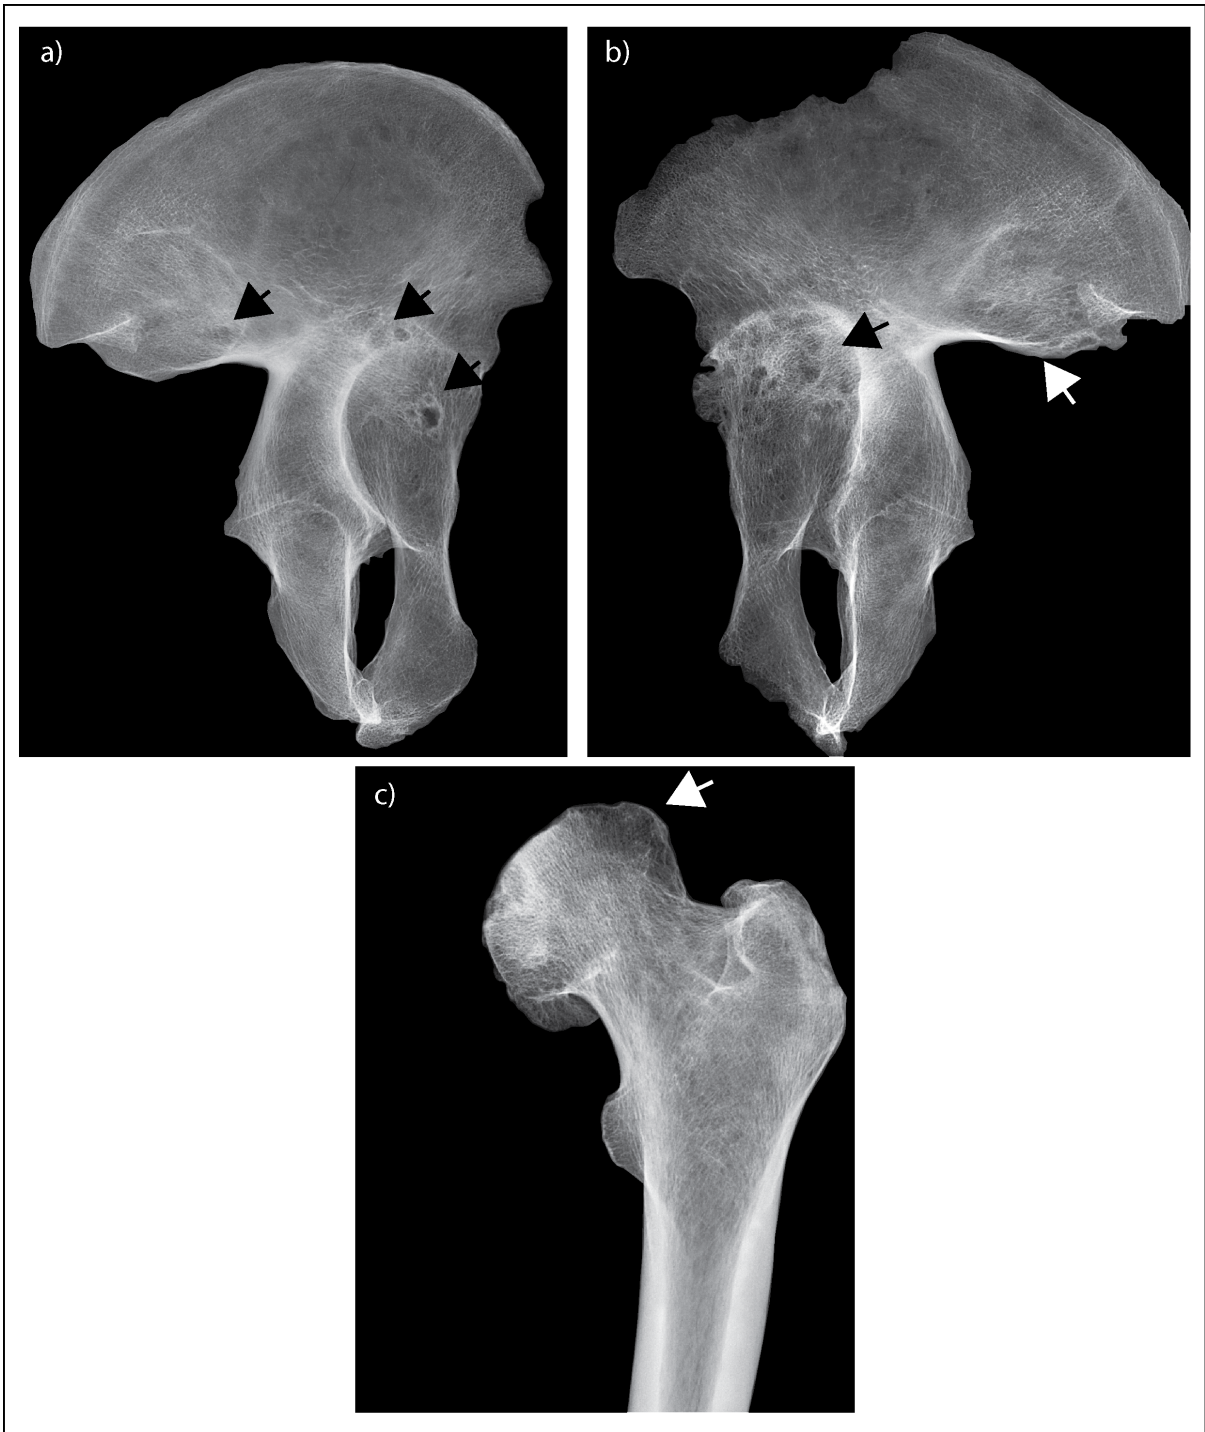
Radiograph of the pathology consistent with possible brucellosis or tuberculosis. a) Multiple osteolytic lesions with minimal sclerosis of the acetabulum of the right os coxa (black arrows). b) Multiple osteolytic lesions with minimal sclerosis of the acetabulum of the left os coxa (black and white arrows). c) Necrosis of the femoral head appears radiolucent on the radiograph (white arrow, AT-865, middle aged adult female, Mungun Taiga culture). Image: author's own.
